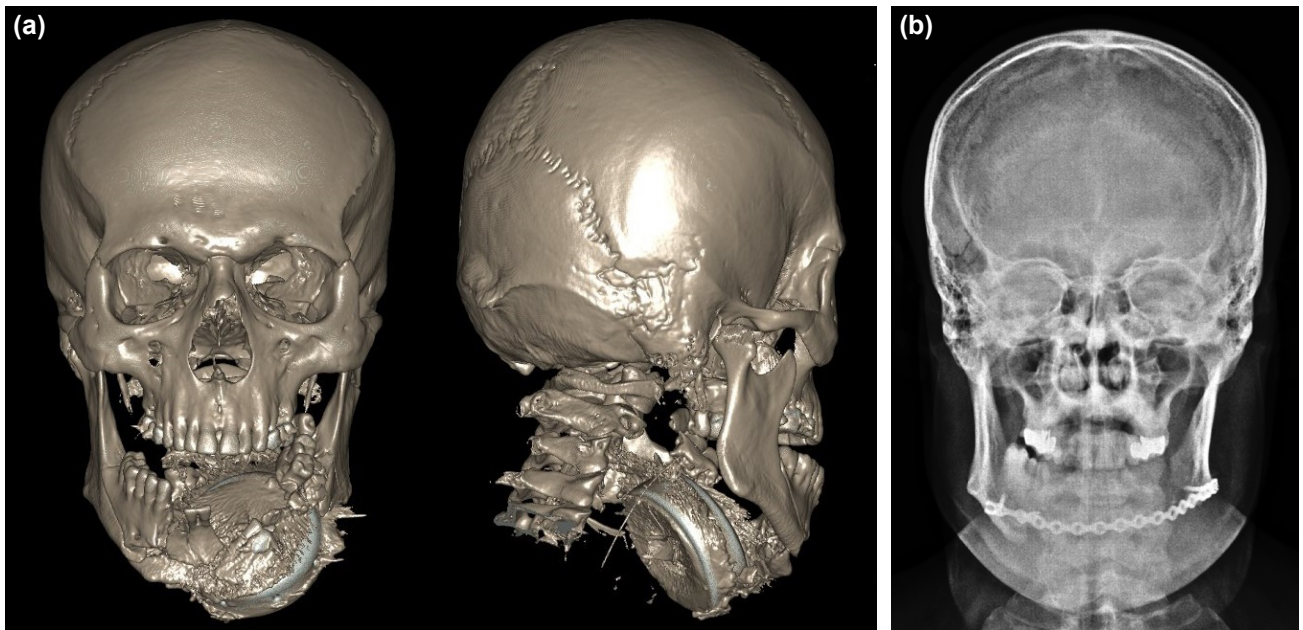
(a) Anterior and lateral oblique view of the three-dimensional computed tomography of the patient. The cover of the steering wheel was embedded into the mandible causing a multi-segment fracture. (b) After excision of the airbag cover and removal of necrotic bone segments, left hemi-mandibular defect was temporarily repaired with plate and screws to prevent its collapse.
